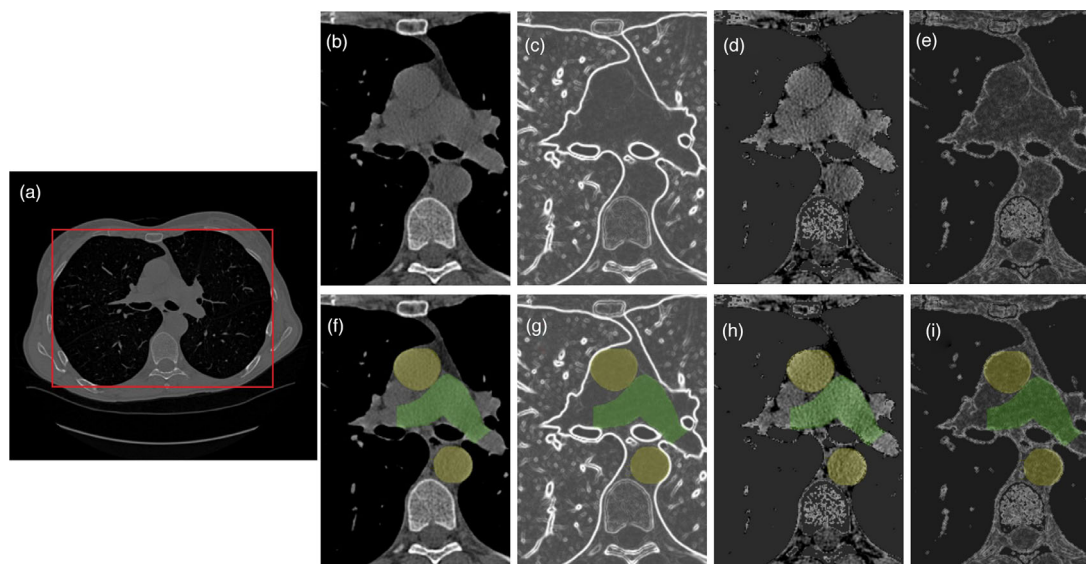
An axial view of a CT scan with the bounding box in red is in (a), zoomed in view of the original scan in (b), and the preprocessed scan in (d). The corresponding gradient magnitude of the original scan is in (c) and the gradient magnitude of the pre processed scan is in (e). Strong edges at lung and bone borders (b, c) are removed during preprocessing (d, e). In the second row (f–i), images are overlaid with the manual PA (green) and aorta (yellow) annotations
